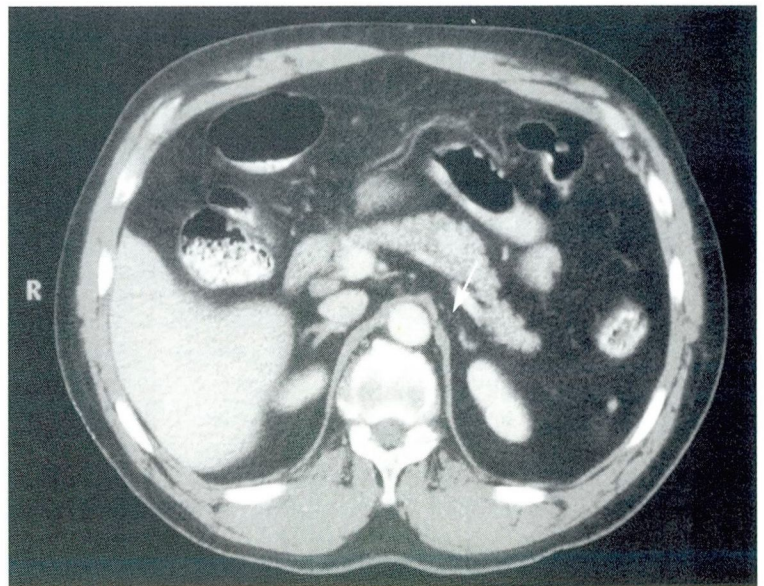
Computed tomographic scan of the pancreas. A 2.5–3.0-cm isodense focal lobulation (arrow) extends anteriorly from the pancreatic body.
